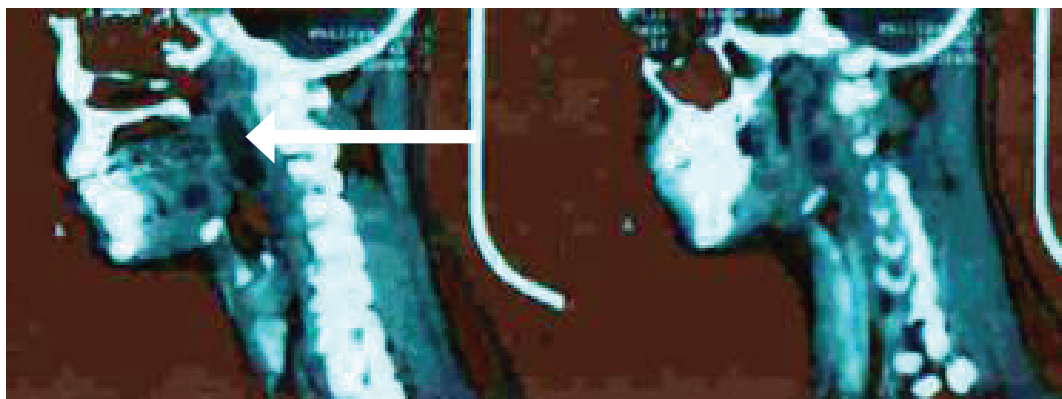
Saggital CT scan shows a well-defined hypodense lesion in Left Parapharyngeal Space (White Arrow)
